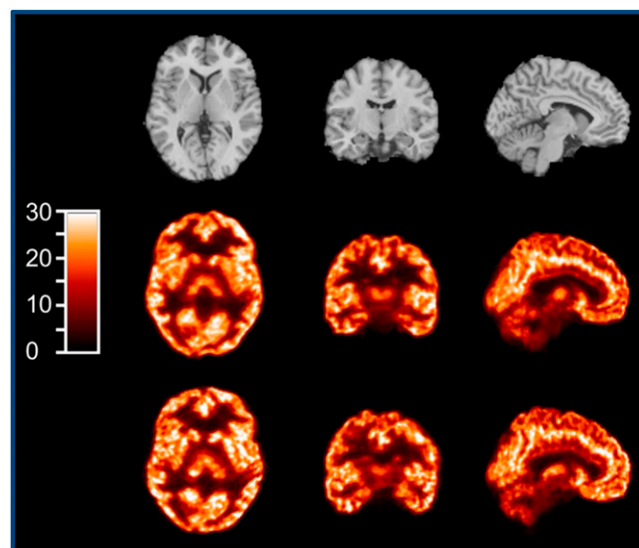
^{18}F -SDM-8 PET imaging of synaptic vesicle glycoprotein 2A in humans. Top: comparative MR images. Middle: ^{18}F -SDM-8 PET. Bottom: ^{11}C -UCB-J PET. The ^{18}F -labeled tracer provided high-quality images, fast and high brain uptake, appropriate tissue synapse distribution throughout the brain, and nondisplaceable binding potentials that were higher than those for the ^{11}C -labeled compound. The availability of a synaptic density tracer with longer half-life allows not only simplified PET procedures but may also lead to multicenter clinical trials to monitor the efficacy of new drugs targeted at synaptic rescue and recovery.
